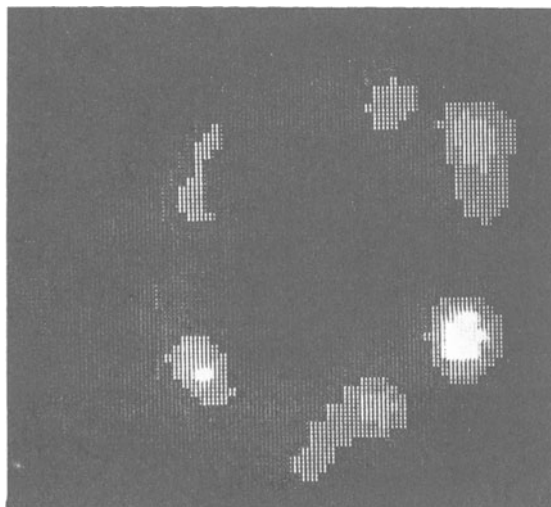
Myocardial scintigram following the injection of  $^{123}\text{I}$ -heptadecanoic acid in a patient with early stage of congestive cardiomyopathy.
